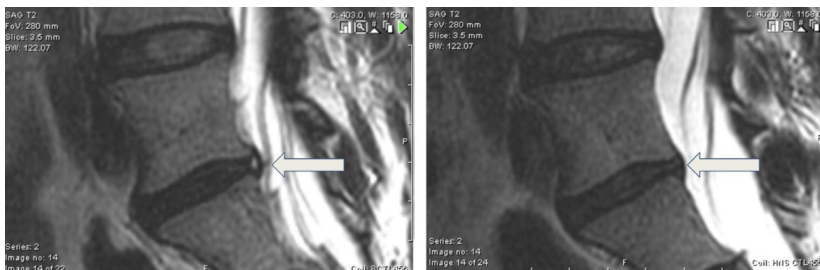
These are magnified MRI images of lumbar spine from a side view (T2-sagittal images). The image on the left is before PRP treatment and shows a white line in the back of the disc (called a high-intensity zone (HIZ)). The HIZ on the MIR represents a tear inside the disc. The image on the right shows the HIZ healed 3 months after PRP treatment.
